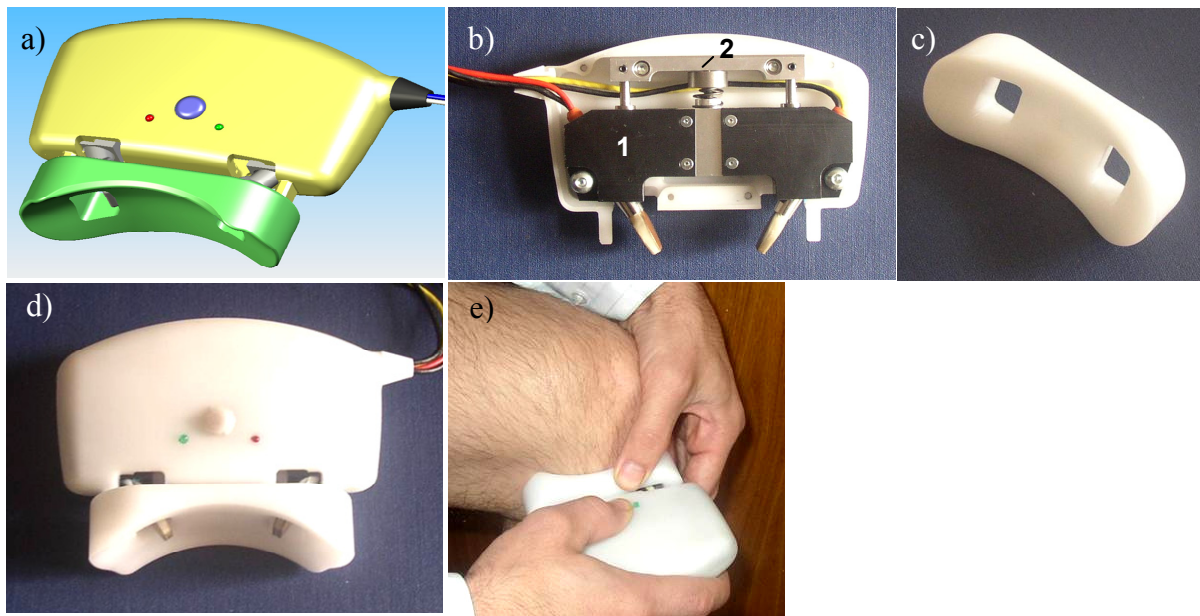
Probe for *in vivo* ultrasonic measurements of proximal tibia. (a): design view; (b): interior showing structure: 1 – holder for the transducers with stiff base and acoustical unbinding sliding along the vertical rails; 2 – immovable frame with springy elements; (c): positioning applicator modelling geometry of the surface of proximal tibia; (d): complete assembly of the probe and the applicator; (e): probe positioned for measurement.
